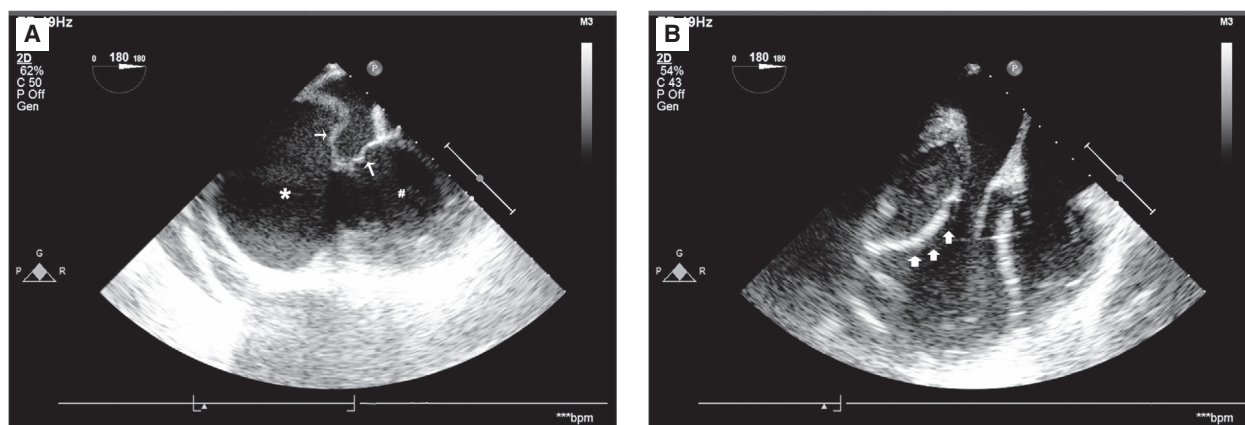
(A) Transoesophageal echocardiogram showing a large submitral aneurysm. (*) indicates the aneurysm; (#) indicates the left ventricle; small arrows indicate the mitral valve. (B) Transoesophageal echocardiogram immediately after surgery showing the Dacron patch (thick arrow) used during surgery to repair the aneurysm.
